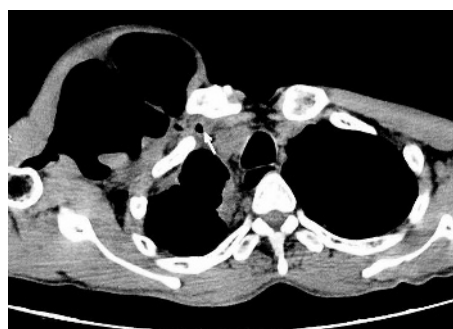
CT scan of chest showing extrathoracic air filled compartment in communication with the right lung (arrow) at the level of the body of the T4 vertebra.
